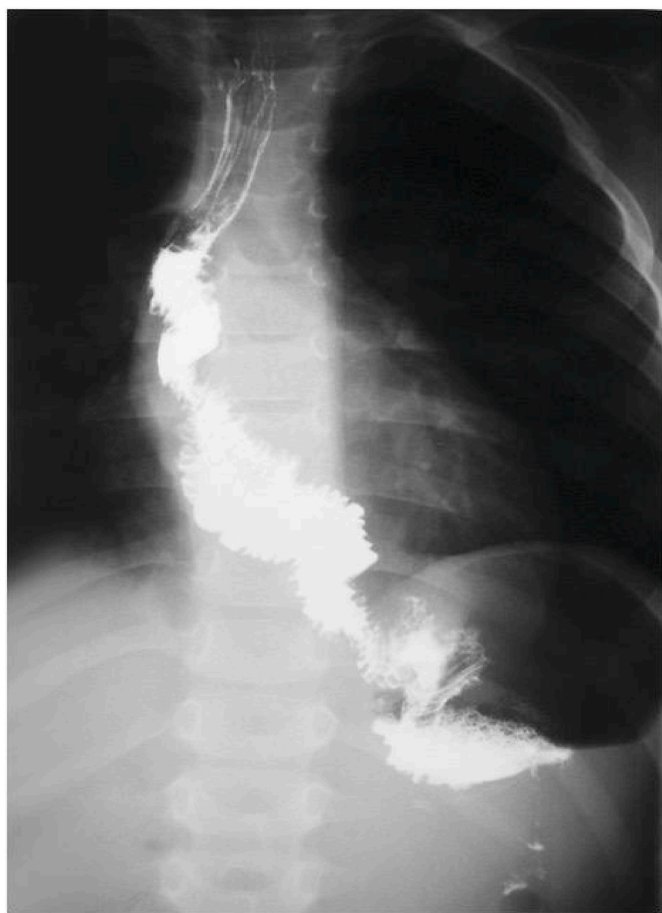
Case 3. Esophageal stenosis. At a distance of 8 years following the surgery, the X-ray barium meal showed a good esophageal transit.
